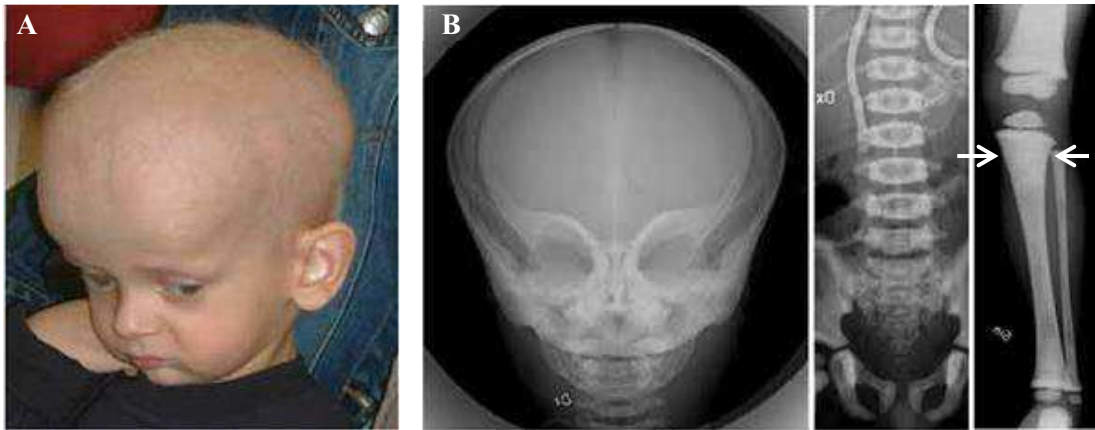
(A) Clinical picture showing the typical facies of an osteopetrotic patient with macrocephaly, frontal bossing and exophthalmos. (B) Representative radiographies showing diffuse increase in bone density, “sign du masque” of the skull, bone-in-bone appearance, absence of bone marrow cavity in the long bones and Erlenmeyer flask deformity (arrows). Adapted from Pangrazio et al., 2013.
